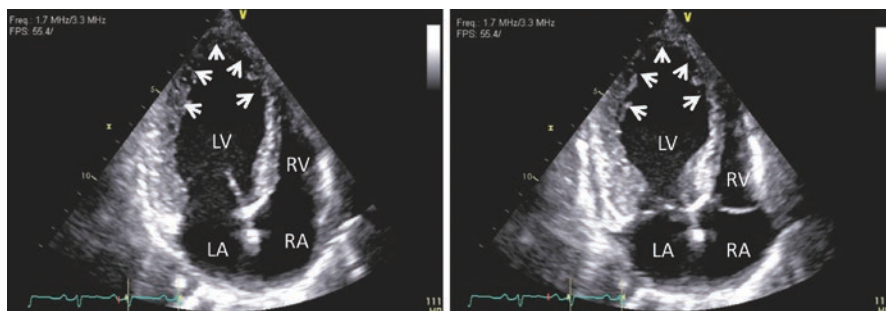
Apical four-chamber view showing stress-induced cardiomyopathy in systole (left) and diastole (right). Arrows indicating ballooning. LA left atrium, RA right atrium, LV left ventricle, RV right ventricle
